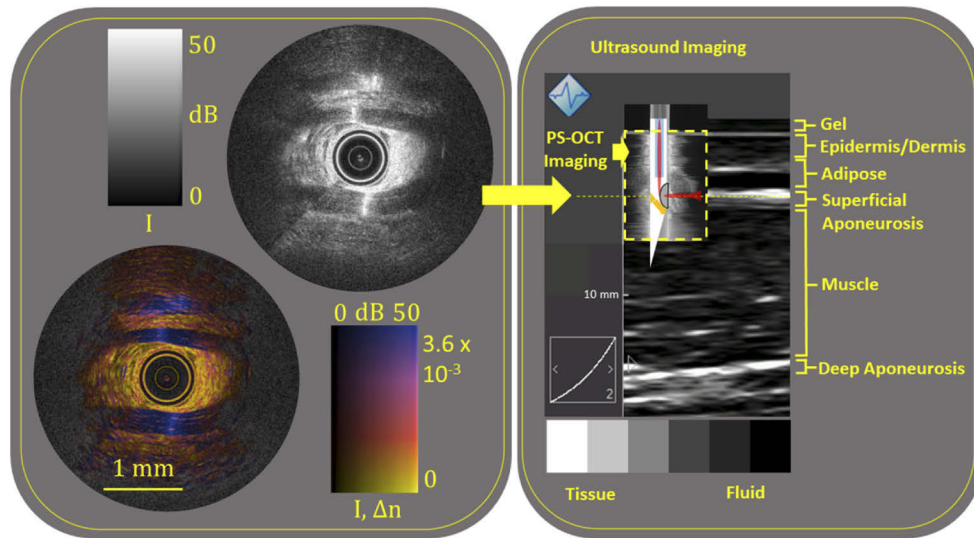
PS-OCT needle probe and laser beam overlaid on the ultrasound image at depths that were reconstructed from PS-OCT alone. Tissue recognition between PS-OCT and ultrasound imaging of skeletal muscle is apparent.
